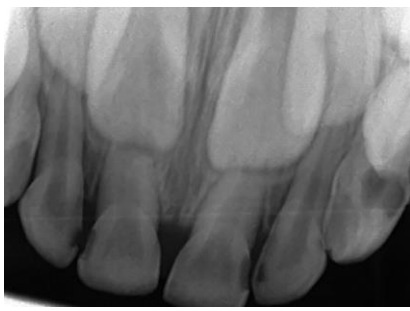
Pre-op maxillary occlusal radiograph
